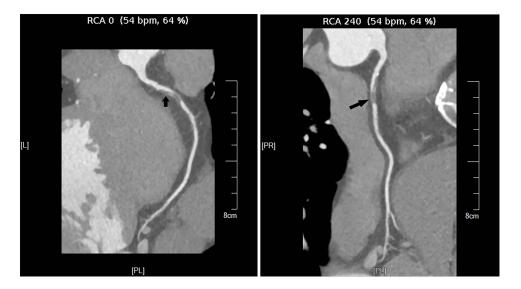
Examination results of a 55-year-old female patient with coronary artery disease. Arrowhead: Coronary CTA test showing calcified lesions in the proximal.
